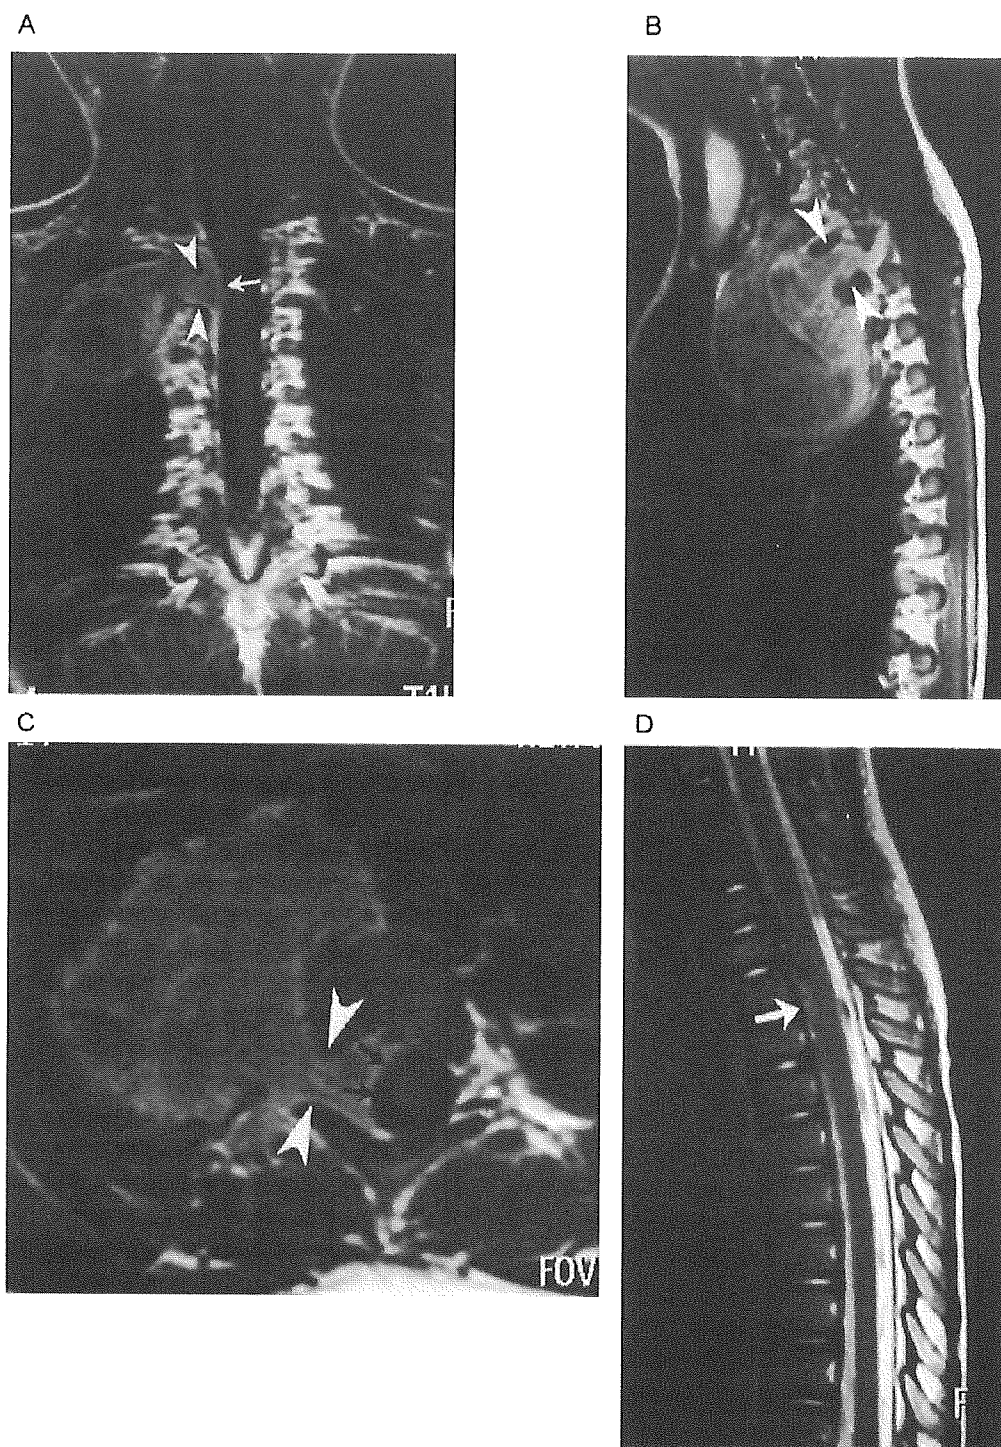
Thoracic neuroblastoma with intraspinal extension in a 2-year-old girl. (A) Gd-enhanced coronal T1-weighted. (B) Gd-enhanced parasagittal T1-weighted. and (C) Gd-enhanced axial T1-weighted image show thoracic mass with a dumbbell extension through an enlarged neural foramen (arrowheads), invading the epidural space (arrows, A). Notice that, although the thecal sac containing the spinal cord is slightly displaced contralaterally, preservation of the subarachnoid spaces around the cord (arrows, C) indicates absence of spinal cord compression. (D) Midsagittal T2-weighted image shows mild amount of pathological tissue in the ventral epidural space (arrow) and a normal spinal cord.
